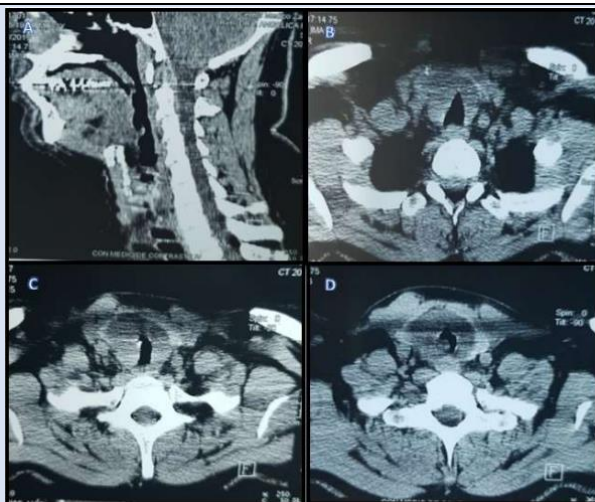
Computed tomography scan of the neck. *Image A:* A coronal projection evidencing the extension of the lesion from the subglottic region (fifth cervical vertebra), a circular mass obstructing 80% of the tracheal lumen. *Image B:* Axial slice at the cervical level showing a 2 cm thick circular tumor, obstructing 80% of the lumen with invasion of the soft tissues of the vocal cords, a 1 cm mass at the base of the left vocal cord. *Image C:* Axial slice at the level of the sixth cervical vertebra. *Image D:* Axial slice at the level of the seventh cervical vertebra.
